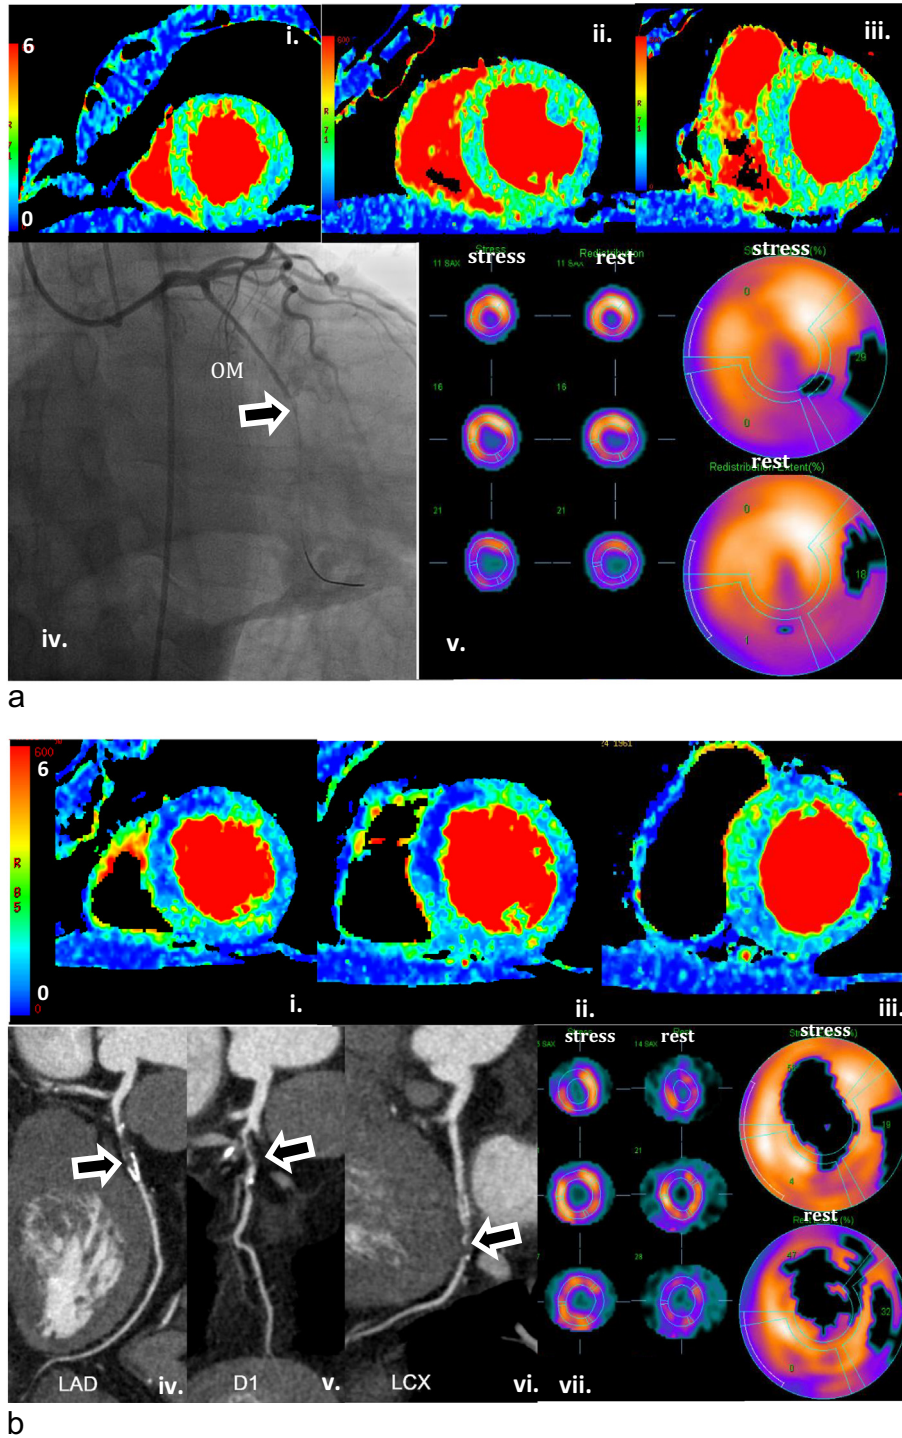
a. This figure shows the case of a 55 y.o. male patient who had a positive treadmill test. The ICA test revealed that he had a single-vessel CAD with a totally occluded obtuse marginal branch (black arrow in iv). The SPECT perfusion maps in the short-axis and polar view revealed a perfusion defect in the basal and mid lateral wall (LCx territory, v). The CT stress perfusion maps in three short-axis slices (i to iii) also revealed ischemia in the lateral wall in the basal and mid slices. b. This figure shows the case of a different 55 y.o. male patient who had exertional chest pain during exercise and was diabetic with a double-vessel CAD. The CCTA images showed that the proximal LAD segment was sub-totally occluded and the proximal LCx segment was 90% stenosed (black arrows in iv to vi), whereas the RCA artery was non-stenosed. The SPECT perfusion maps in the short-axis and polar view (vii) showed profound hypoperfusion in the lateral wall (LCx territory) and apical wall (LAD territory). The CT stress perfusion maps in three short-axis slices (i to iii) also showed intense hypoperfusion in approximately the same lateral and apical myocardial segments. c. This figure shows the case of a 59 y.o. male patient who had a triple-vessel CAD and unstable angina. He had a prior myocardial infarction (non-STEMI) and a stent was implanted in the proximal LAD artery about 17 months before his enrolment for this study. The ICA showed that the proximal and mid RCA segments were 70% and 99% stenosed respectively (black arrows in iv); the mid LAD segment was 60% stenosed, with additional 80% and 70% stenosis in the first and second diagonal branches respectively (black arrows in v); the distal LCx segment was totally occluded. The SPECT perfusion maps in the short-axis and polar view (vi) showed absence of or minimal hypoperfusion due to the “balanced” ischemia commonly seen in multi-vessel CAD. By contrast, the CT stress perfusion maps in three short-axis slices (i to iii) clearly showed ischemia in all three coronary territories.
